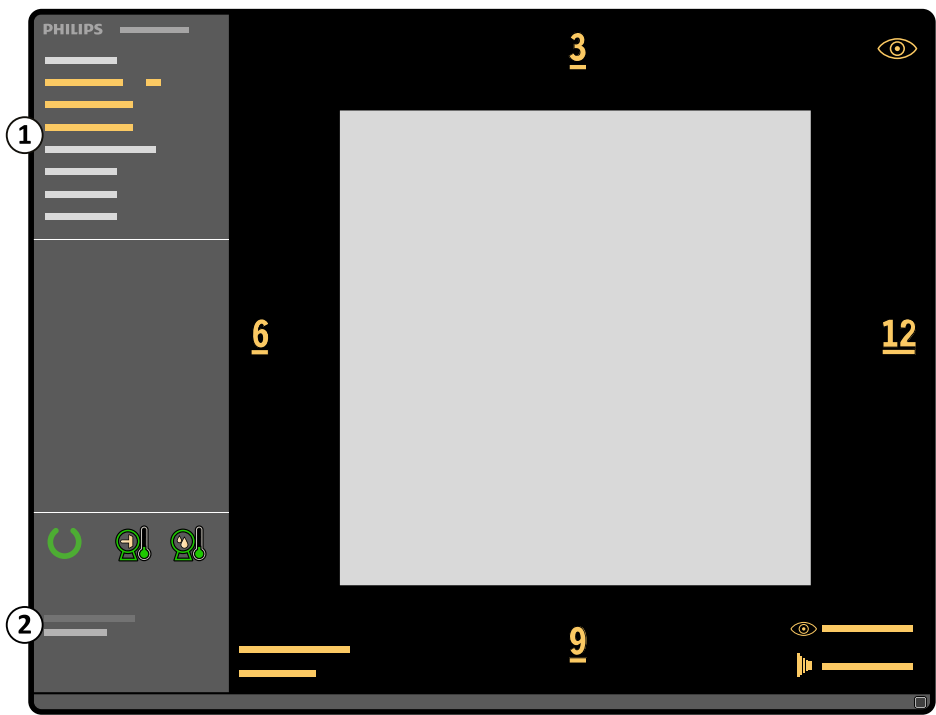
Single image screen – Live X-ray – mobile view station
